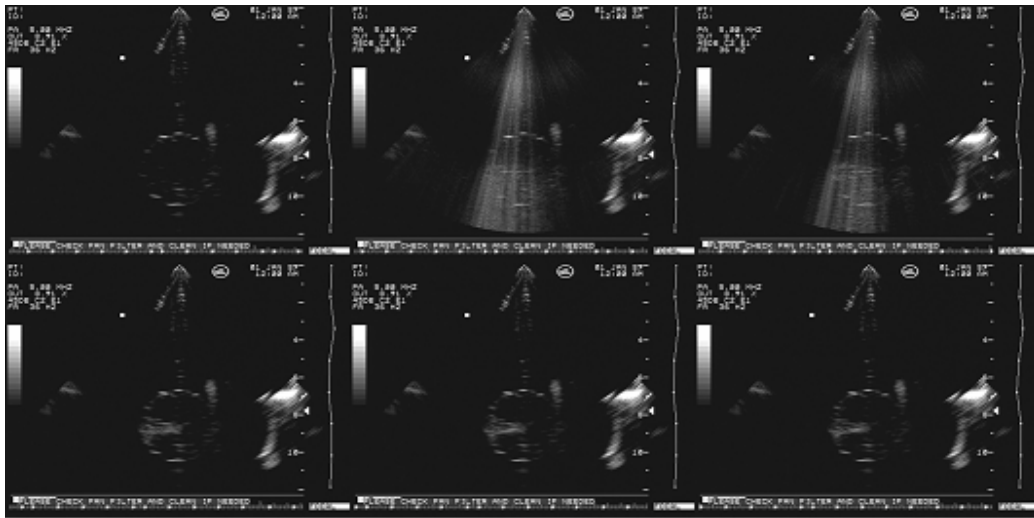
PLA microbubbles excited by an ultrasonic pulse of 400 mVpp.
